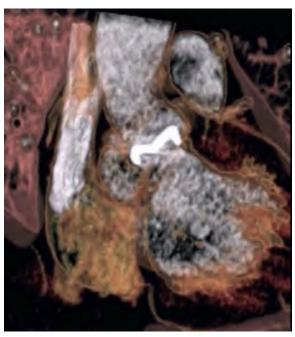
Multislice computed tomography scan showing perivalvular abscess. (Courtesy Dr. Nandan Anavekar, Mayo Clinic.)
